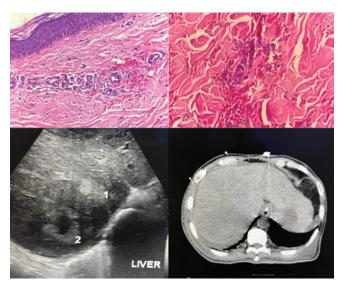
Microsection showed basket-woven stratum corneum, flat epidermis with scattered necrotic keratinocytes, blood vessels exhibiting endothelial cell swelling, fibrinoid necrosis of vessel walls, and eosinophilic thrombi within the lumen. The whole abdomen ultrasound showed a hyperechogenic focus and a hypoechogenic lesion with rim hyperechogenicity in the right hepatic lobe, while a plain computed tomography scan revealed an enlarged heterogeneous liver with retroperitoneal lymphadenopathy
